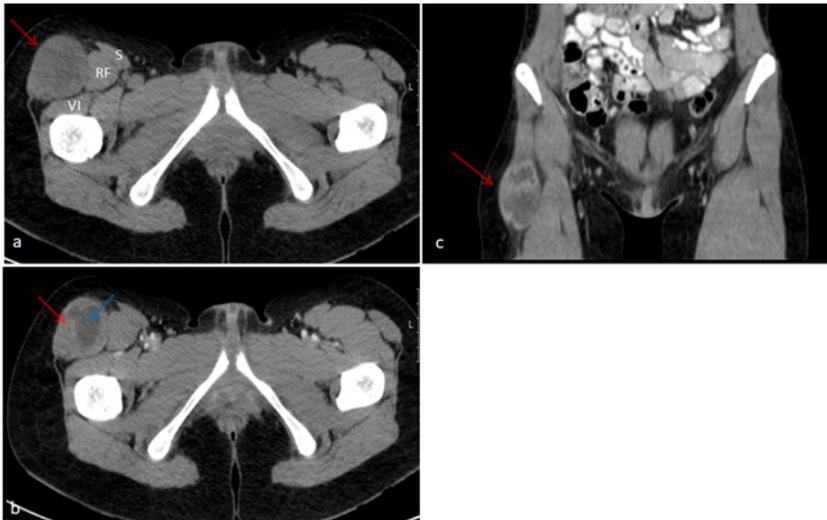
Computed Tomography (CT) of the proximal thighs. Axial non-enhanced image (a) shows a low attenuation mass (red arrow) on the muscular plane of the proximal right thigh lateral to the sartorius (S) and rectus femoris (RF) and anterior to the vastus intermedius (VI). Axial contrast enhanced image (b) reveals solid (red arrow) and cystic (blue arrow) components of the mass. Coronal contrast enhanced image (c) shows that the mass has a fusiform shape with well-defined contours.
